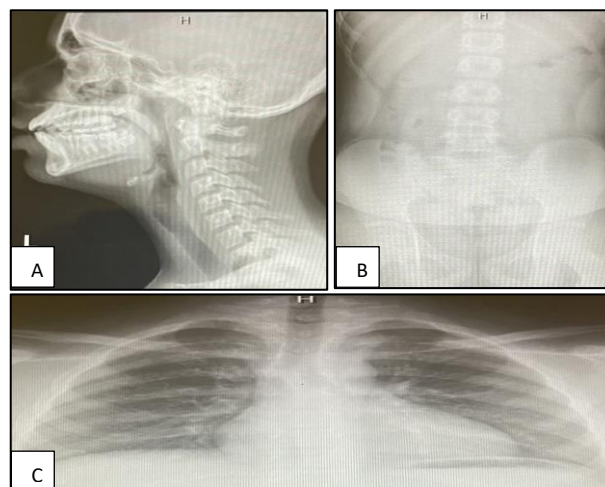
(A-C): Lateral soft tissue neck X-ray showing no foreign body, AP view of abdomen with no foreign body and X-ray chest showing no foreign body.
